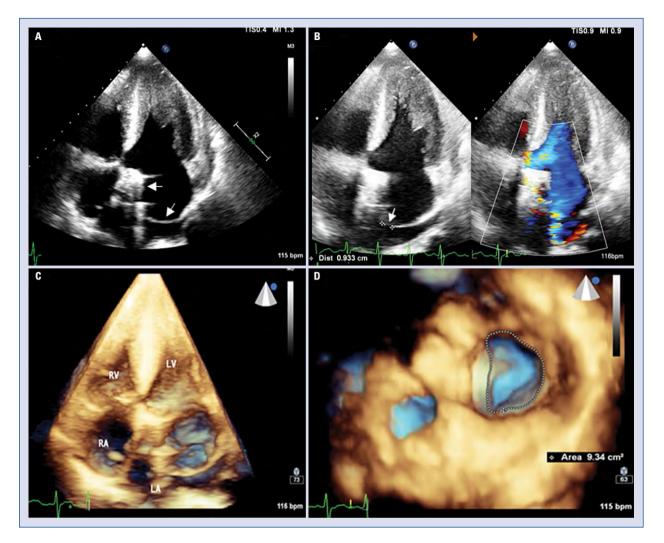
A. Bedside transthoracic echocardiography (TTE) revealing a severe atrioventricular disruption and left atrial dissection (arrows) in the apical 4-chamber view; B. Color Doppler imaging shows that the dissected cavity directly communicated with left ventricle via a massive atrioventricular separation. The dissected cavity also communicated with true left atrium through a 9-mm defect (arrow); C. Three-dimensional TTE intuitively displaying the dissected left atrium wall; D. Three-dimensional TTE from the left ventricular perspective showing the extent of atrioventricular separation (9.3 cm²); LA — left atrium; LV — left ventricle; RA — right atrium; RV — right ventricle.
